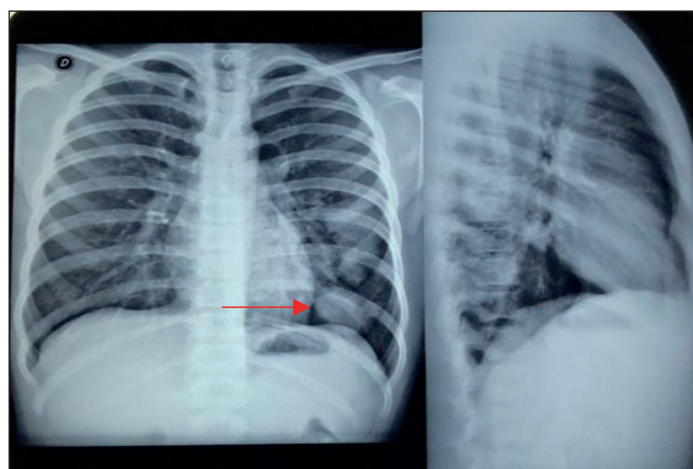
Initial Chest X-ray: Nodular images at the left lower lung lobe.
